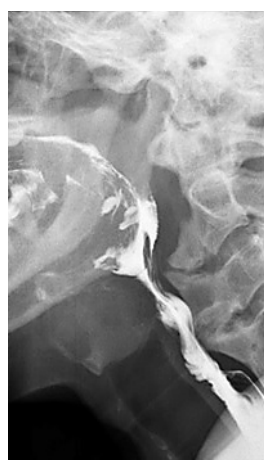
Barium swallow lateral X-ray of oesophagus
